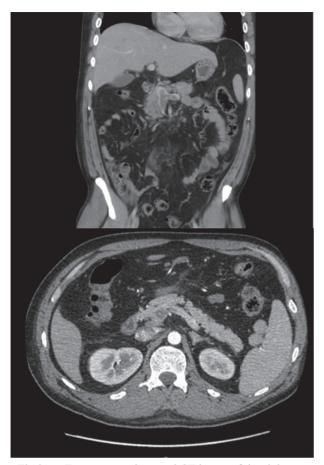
Transverse and coronal CT image of the abdomen showing thrombosis of the superior mesenteric vein and the splenic vein progressing into the portal vein.
